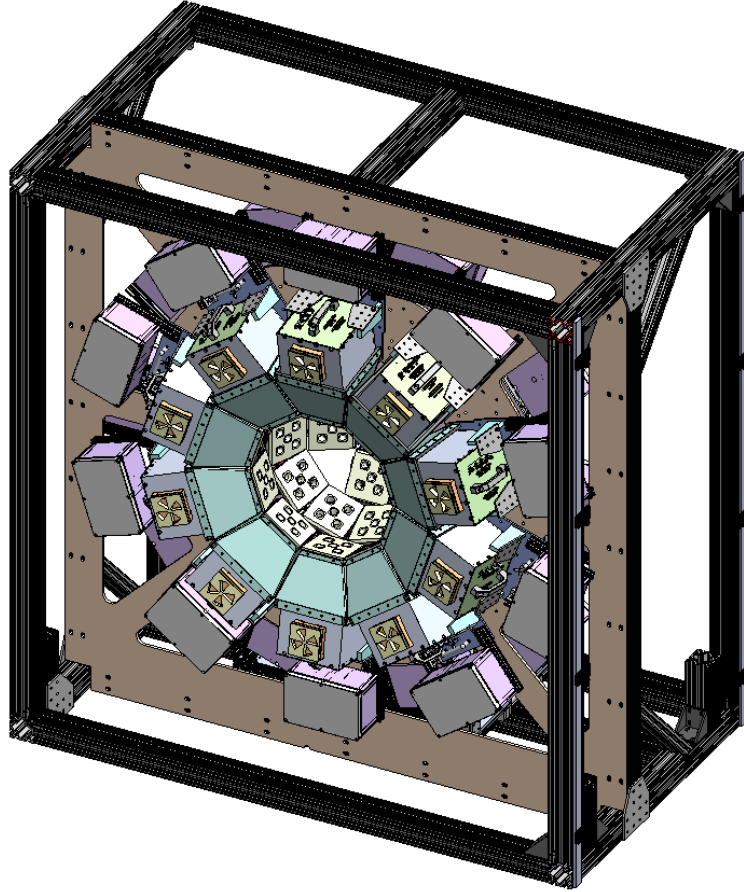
Solid Works figure showing AdaptiSPECT-C design. Image courtesy of Garrett Richards.
